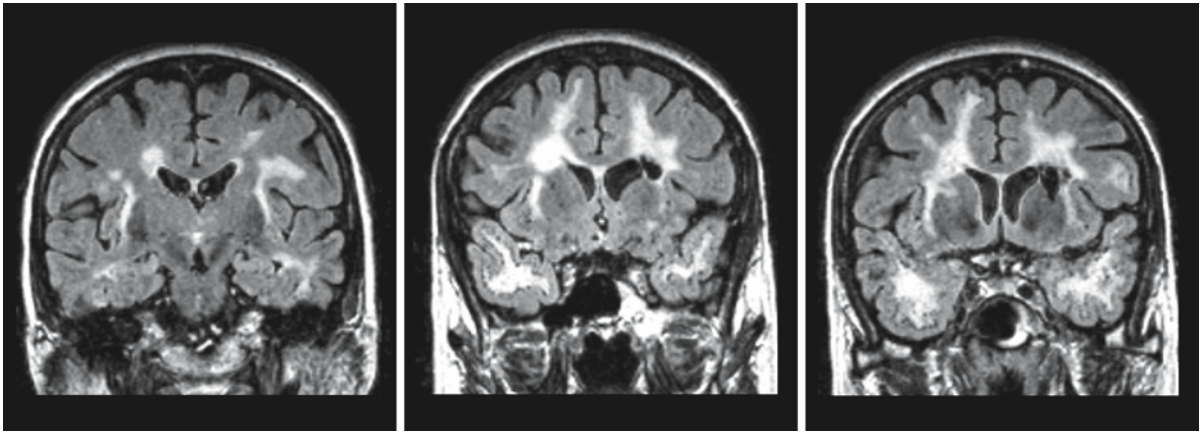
(*continued*). Series of FLAIR images in a 59-year-old woman, a representative of a known CADASIL family. In this series many MR characteristics of CADASIL are present: more or less symmetrical involvement of the centrum semiovale, external capsules, temporal lobes, and basal ganglia; multiple lacunar infarctions; some involvement of the cerebellum. Even on the FLAIR images the basal ganglia have a relatively low
